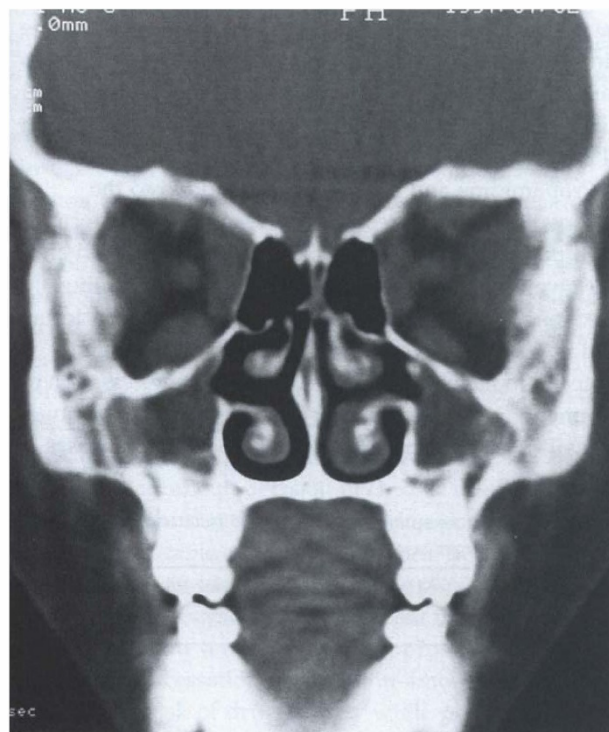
CT scan of the orbits, coronal view, demonstrating gross enlargement of the extraocular muscles, mucosal thickening in both maxillary antra and swelling of the left inferior turbinate.
